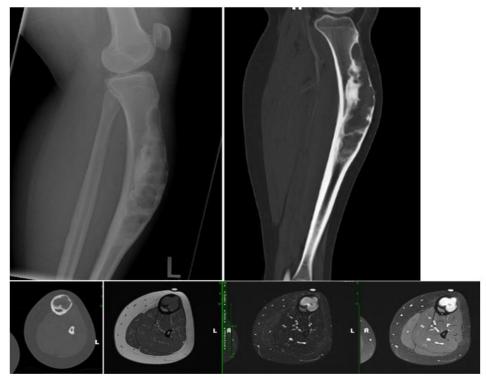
Benign bone lesion in a 15-year-old girl. (Top) Lateral radiograph and sagittal CT reconstruction of the left tibia demonstrate a well-defined, geographic, cortically based, diaphyseal mixed lytic and sclerotic lesion along the anterior tibia with marginal sclerosis and areas of dense osteoid mineralization. (Bottom) Axial CT, T1-weighted, STIR, and contrast-enhanced MRIs demonstrate a lytic lesion with fibrous matrix involving the anterior tibial cortex with circumferential sclerosis, which encroaches on but does not invade the medullary cavity. Biopsy-confirmed osteofibrous dysplasia
